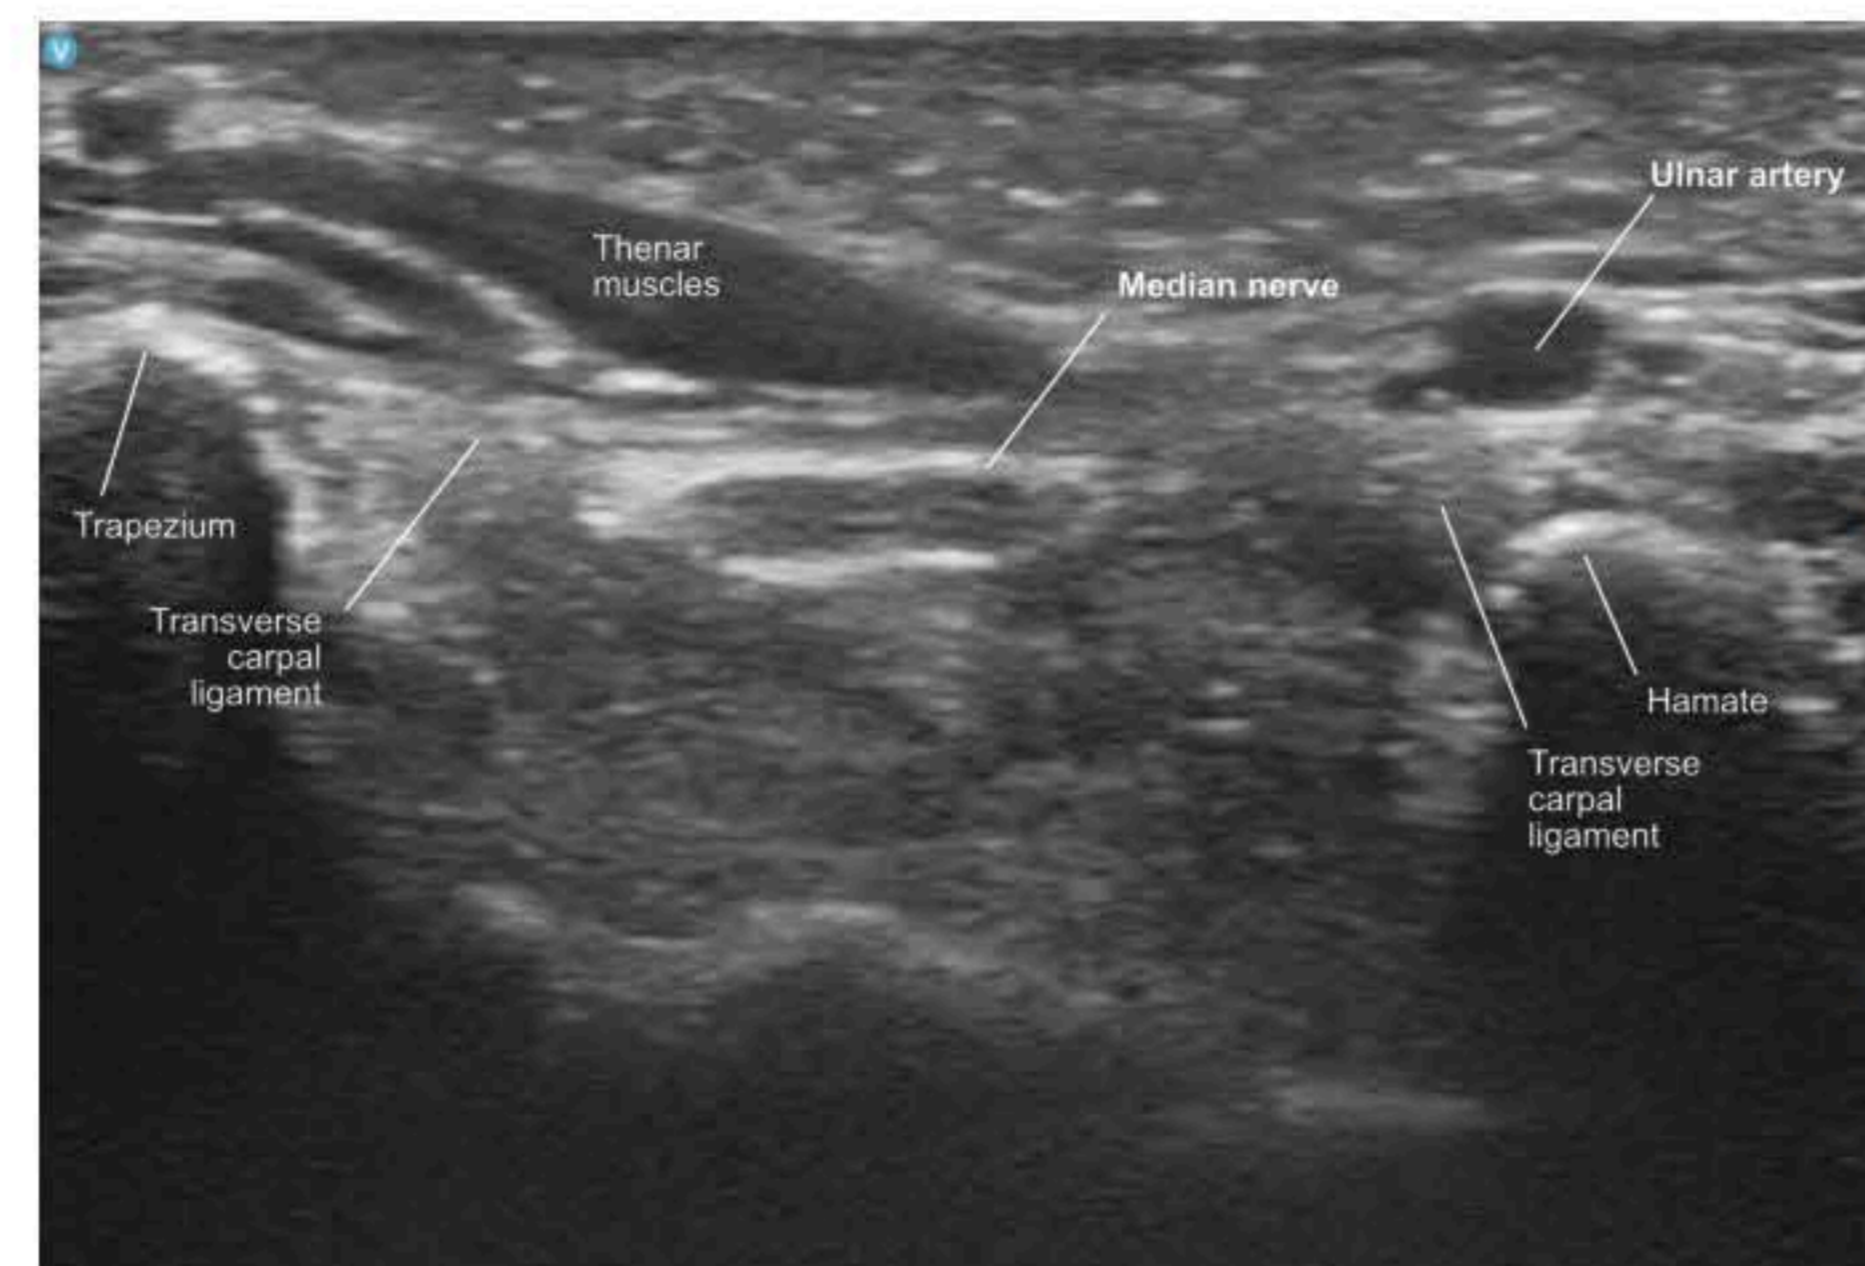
Short axis ultrasound view of the carpal tunnel at the site of maximal constriction: beneath the thickest portion of the transverse carpal ligament.
